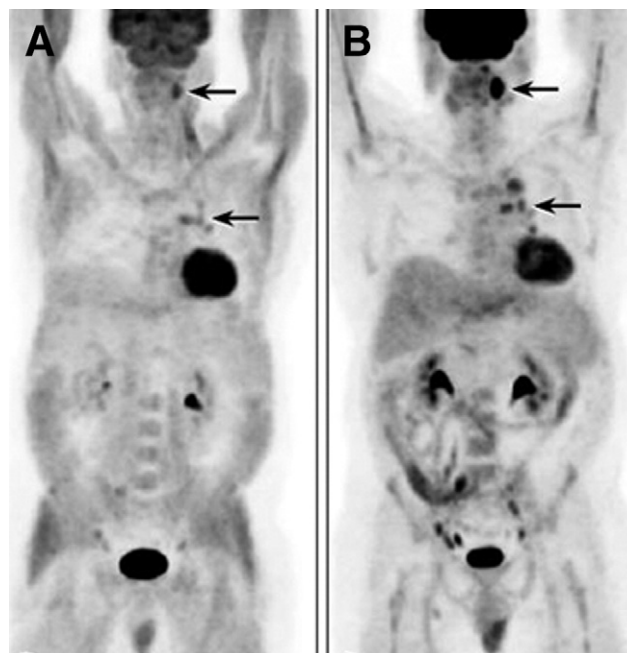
Effect of sudden increase in insulin levels on FDG-PET. In a patient undergoing staging of lymphoma, the FDG-PET scan (A) was performed after the patient had eaten a candy bar 30 minutes before FDG injection. Note the extensive myocardial and muscle uptake caused by high insulin levels. Diminished activity is seen in the brain and in tumor sites in the neck and chest (arrows). A repeat study (B) after the patient complied with routine fasting shows more normal biodistribution of tracer and better visualization of tumor foci (arrows).
